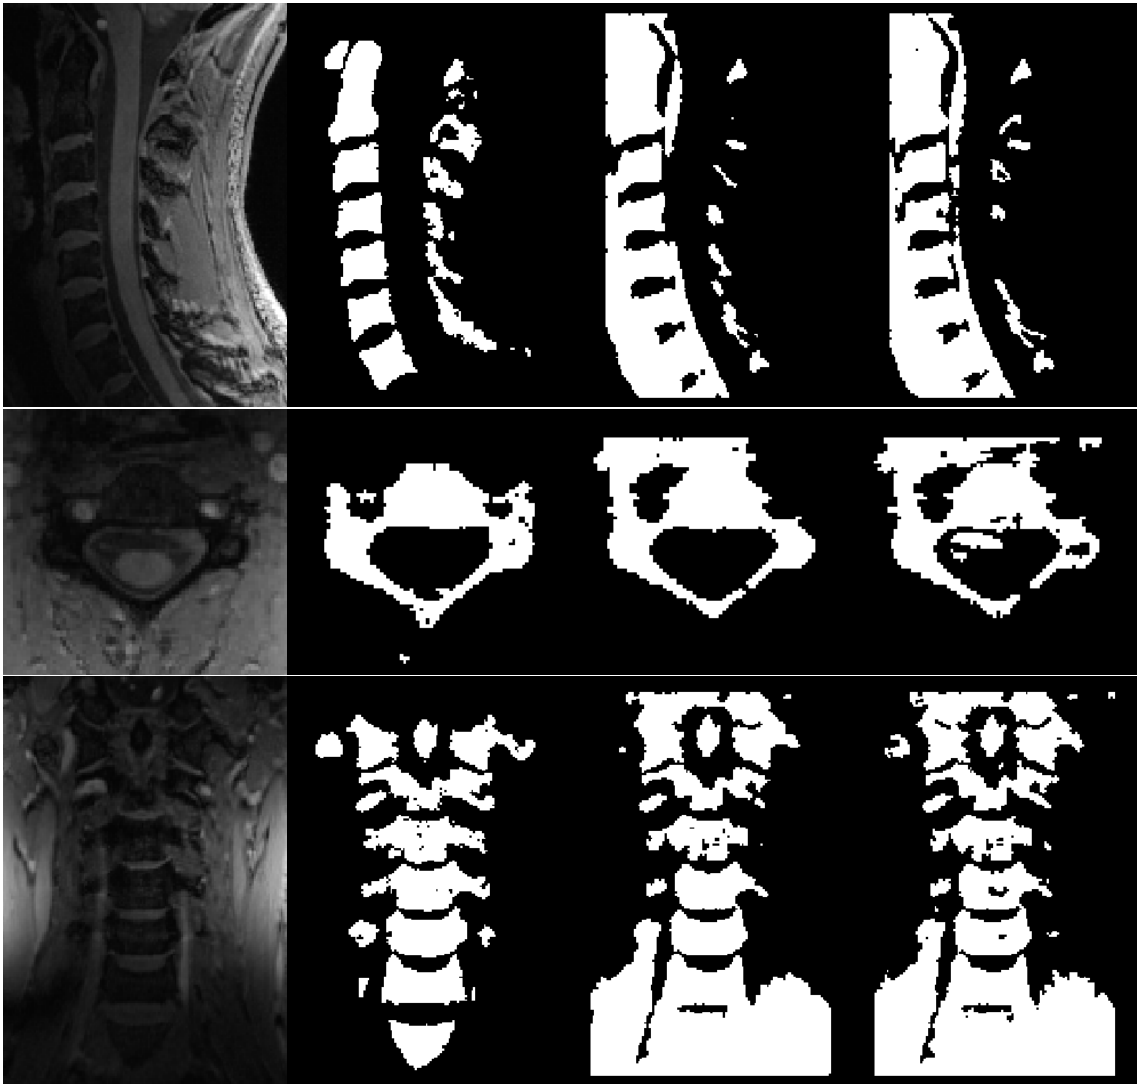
Comparison of segmentations from different methods. From left to right: a) MRI, b) manual segmentation, c) semi-automatic segmentation, and d) automatic segmentation. Top to bottom, the sagittal plane, the transverse plane and the coronal plane.
